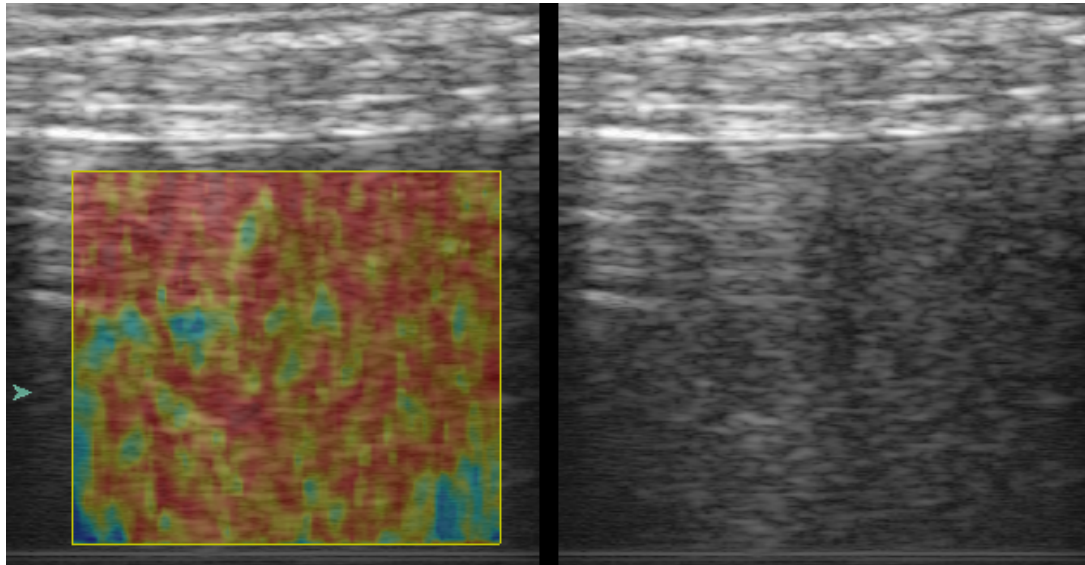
Elastography recordings with Ultrasonix method with reverberations
